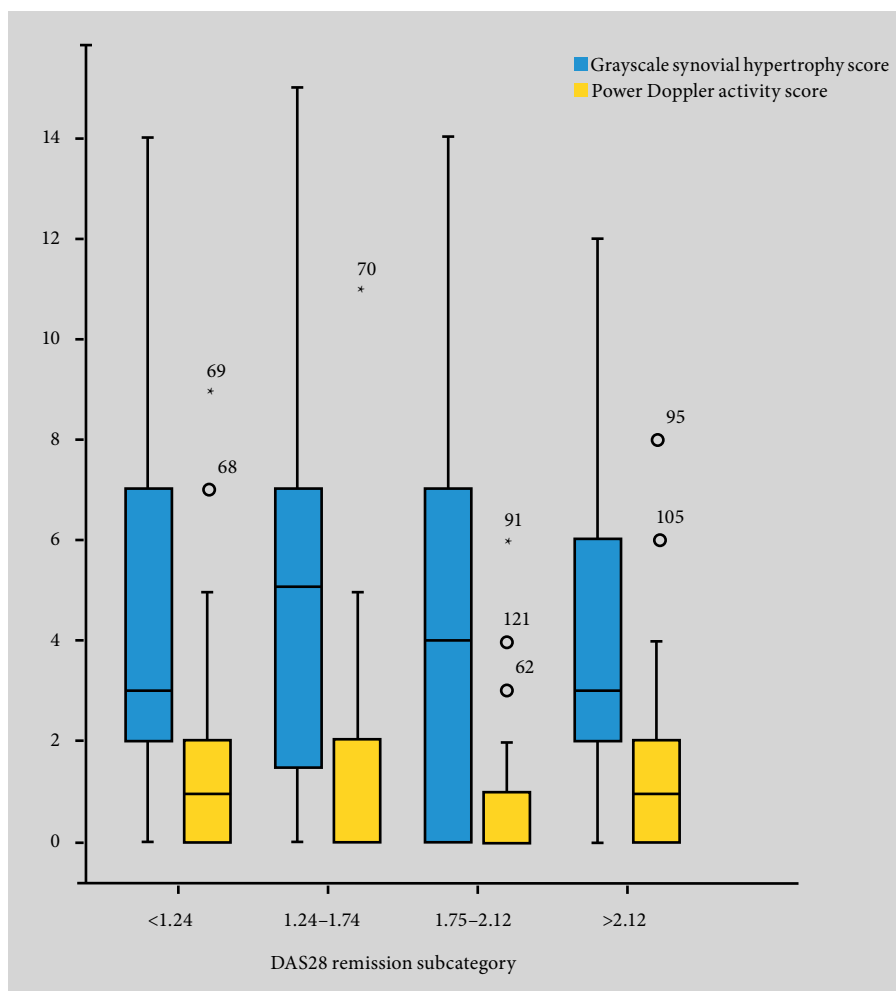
The relationship between stringent DAS28 subcategories of remission and total median power Doppler activity and total median grayscale synovial hypertrophy score per patients as detected by ultrasound. No significant difference was seen between the groups. DAS28, 28-joint disease activity score; GS, grayscale. Reproduced with permission from Saleem et al [28] ©BMJ.
